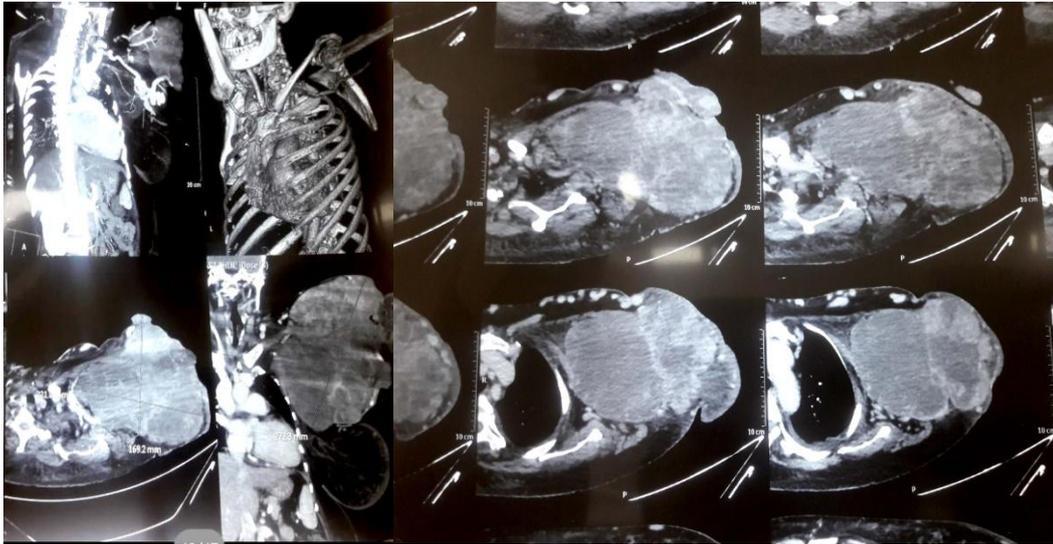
(A) & 2 (B): CT/MRI images show heterogeneous mass anterior to shoulder
